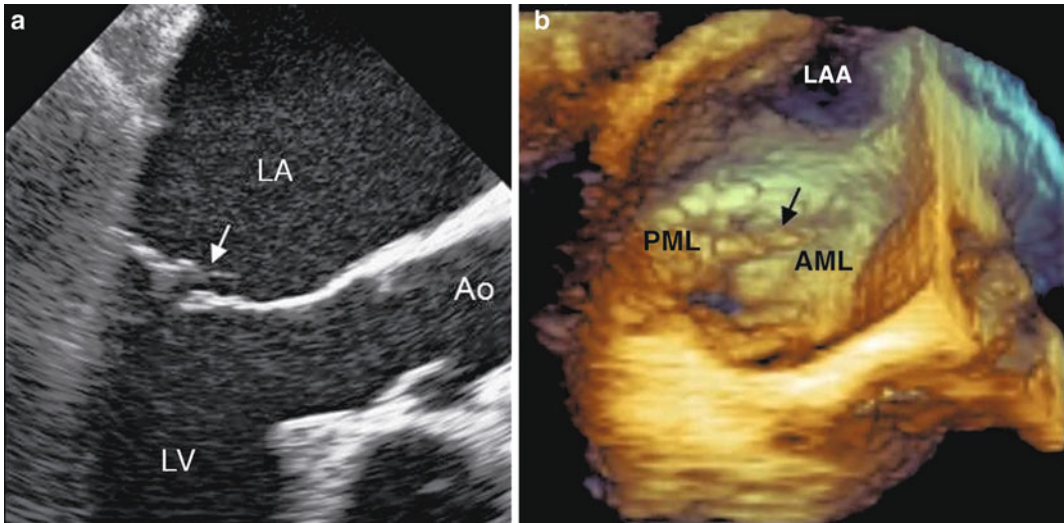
a Transesophageal long-axis two-dimensional image of an 84-year-old patient with prolapse and rupture of a chorda tendinea of the posterior leaflet. The arrow indicates rupture of a small chorda tendinea of the central segment of the posterior leaflet. It is shown how the anterior leaflet does not have the characteristics of a myxomatous leaflet, but appears substantially normal; b transesophageal three-dimensional echocardiography
